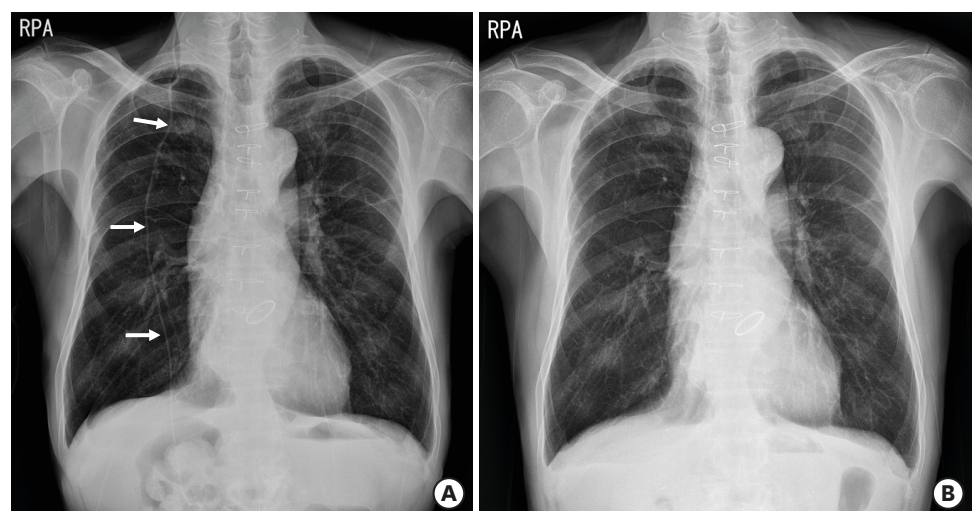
(A) Last chest plain radiograph taken 5 months before symptom presentation of the patient. At that time, the distal shunt catheter was clearly seen (white arrows). (B) A chest plain radiograph was taken immediately after noticing that the distal catheter was missing from the outside film completely by chance. The distal catheter that was seen in the previous plain radiograph was gone.
